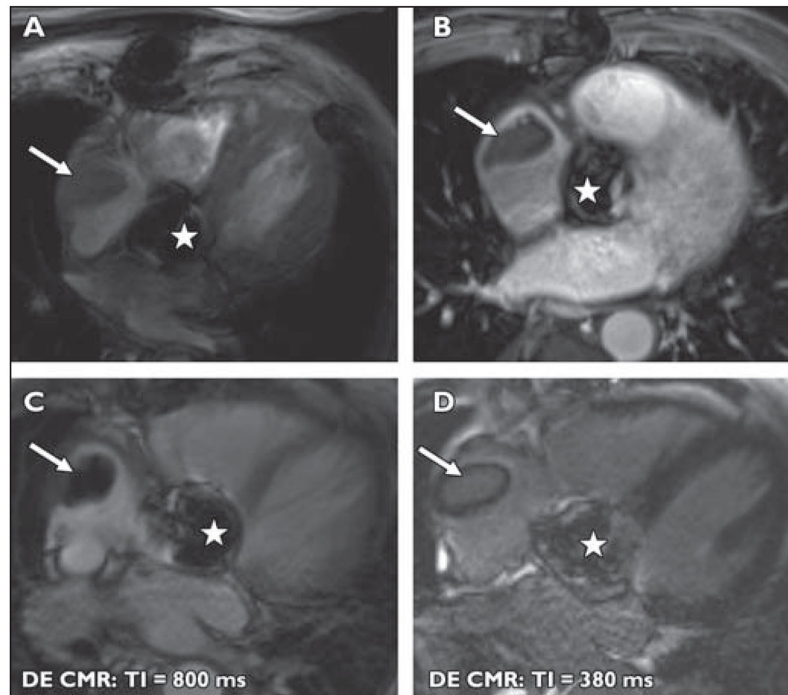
76-year-old man with history of lymphoma and atrial fibrillation who was found to have right atrial mass on echocardiography. The patient had undergone aortic valve replacement 12 years previously
